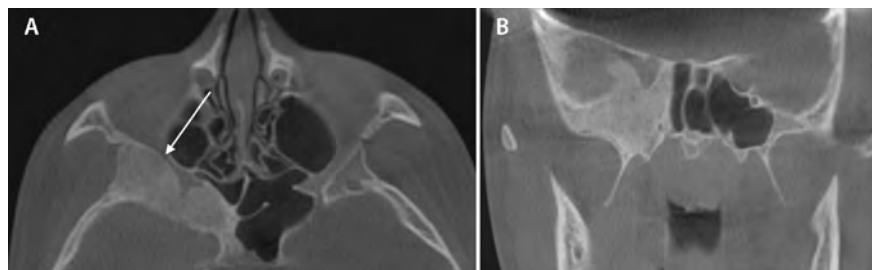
Fibrous dysplasia in an asymptomatic patient presenting for orthodontic treatment. Data acquired using an iCAT CBCT machine. Images are reformatted in iCATVision software. (A) Axial view at the level of the orbits shows fibrous dysplasia posterior to the right orbit and constriction of the optic canal (arrow). (B) Coronal view at the level of sphenoid sinus shows the fibrous dysplasia is encroaching into the middle cranial fossa. This fibrous dysplasia was not detected on panoramic radiograph.
